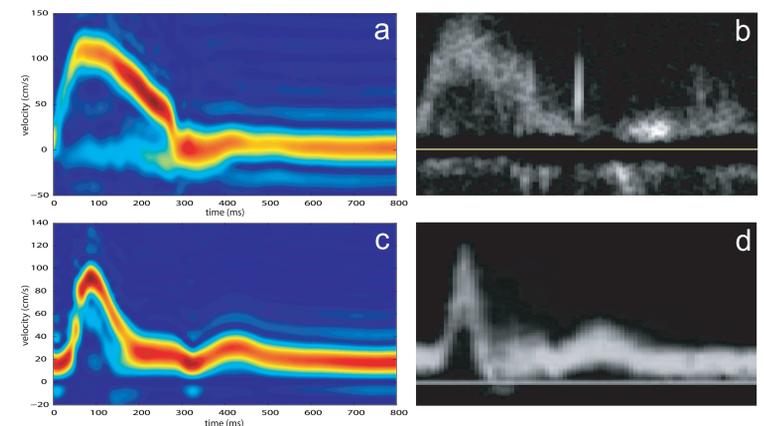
Time-velocity flow histograms from the aortic valve, (a) Spiral FVE, (b) Doppler ultrasound, and from the common carotid artery, (c) Spiral FVE, (d) Doppler ultrasound.
